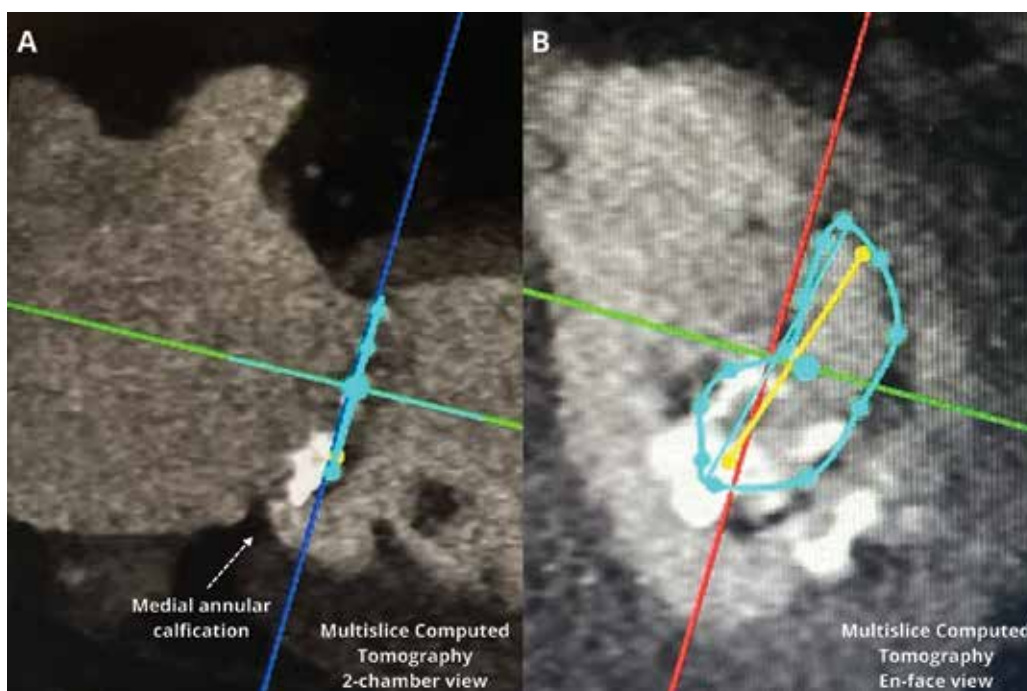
Multislice computed tomography of the mitral valve: A. 2-chamber view; B. En-face view.
